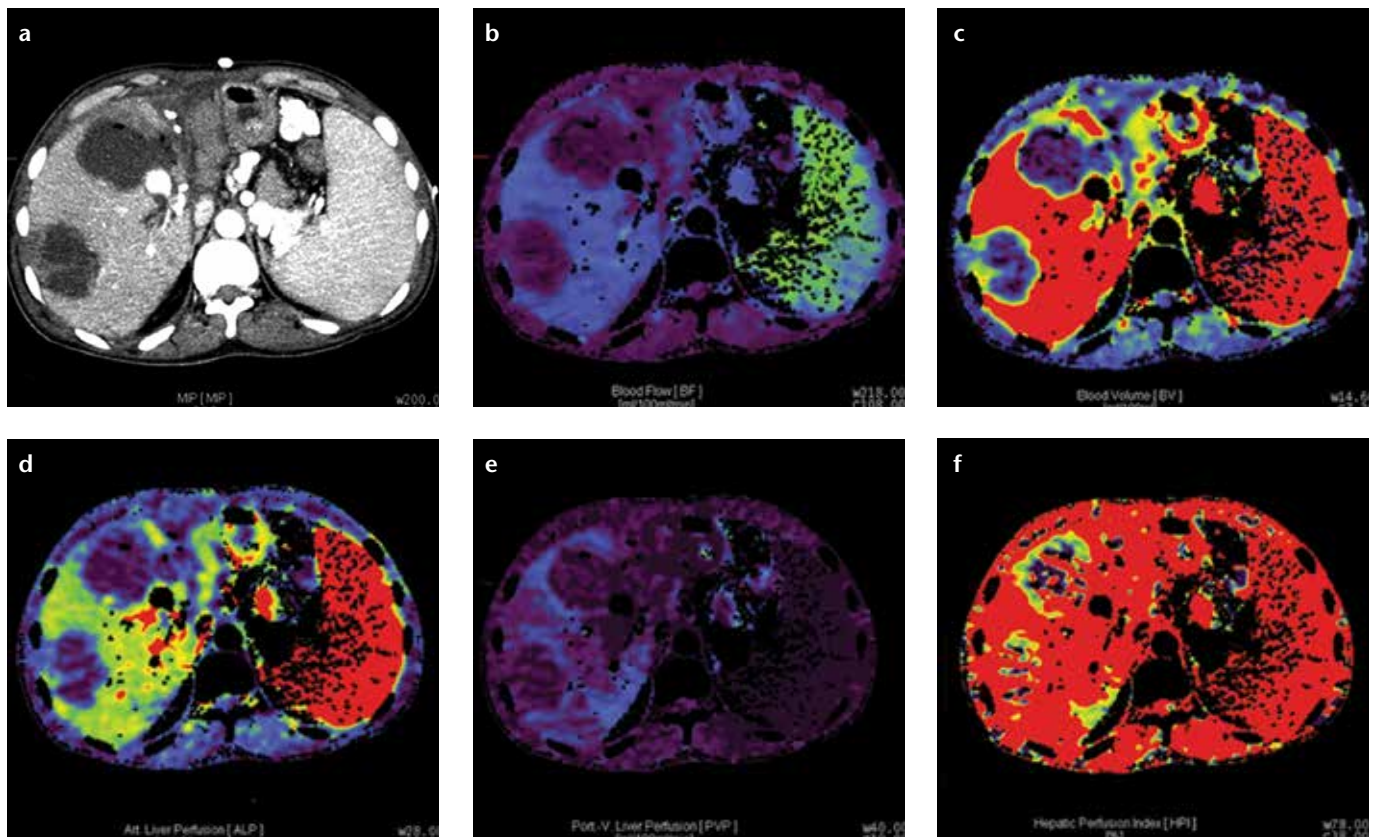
a–f. Axial perfusion images (a) and functional CT perfusion map (b–f) of a 39-year-old man with hepatic arterial occlusion after living donor liver transplantation. The perfusion images show decreased BF, BV, ALP, PVP, and HPI at the necrotic area.
